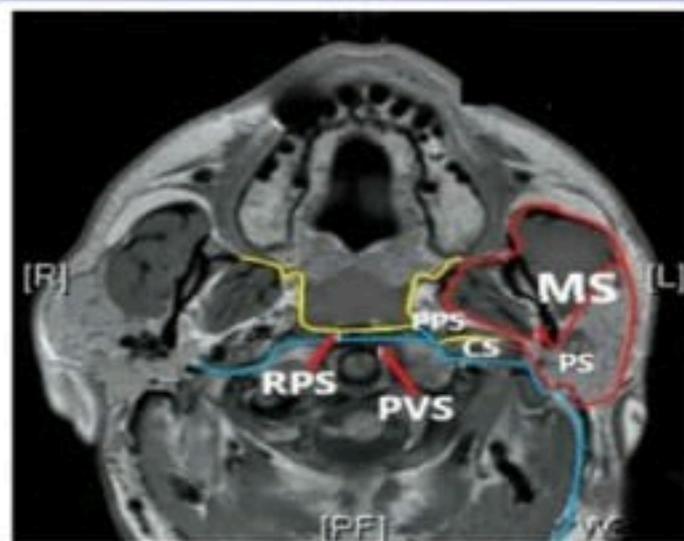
MRI Neck-axial section-at nasopharynx level- (Courtesy: [www.entokey.com](http://www.entokey.com))
